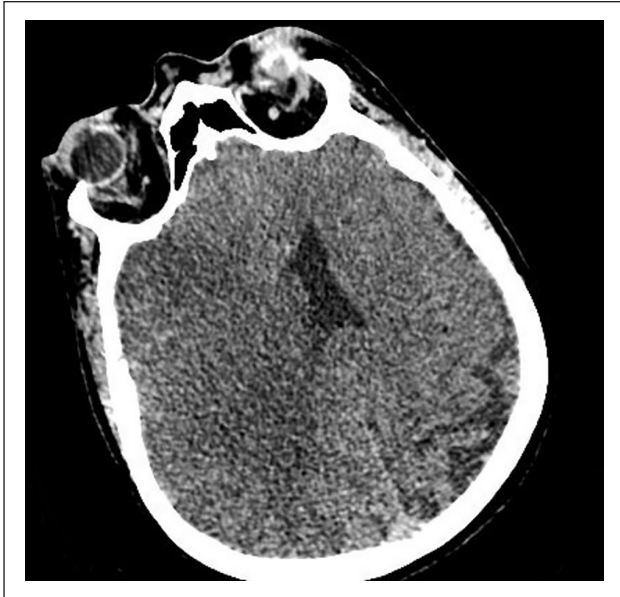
Head CT axial section with malignant MCA infarct but no mass effect.
